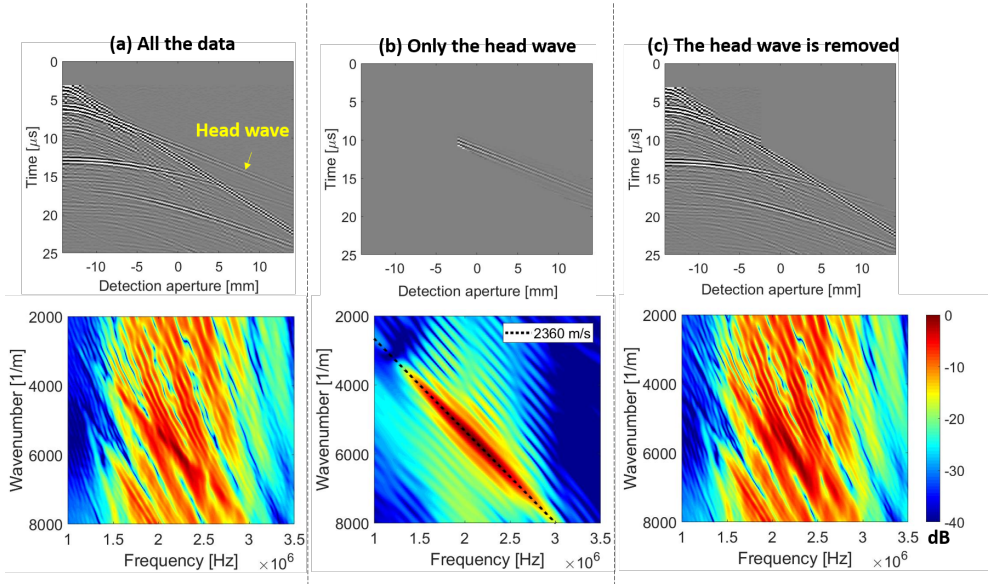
Experimental space-time domain data and the corresponding f - k representation. A P4-1 ultrasound probe and a PVC slab with a thickness of 8 mm were used in the experiment. (a) All the data. (b) Only the head wave. (c) Head wave is removed.
